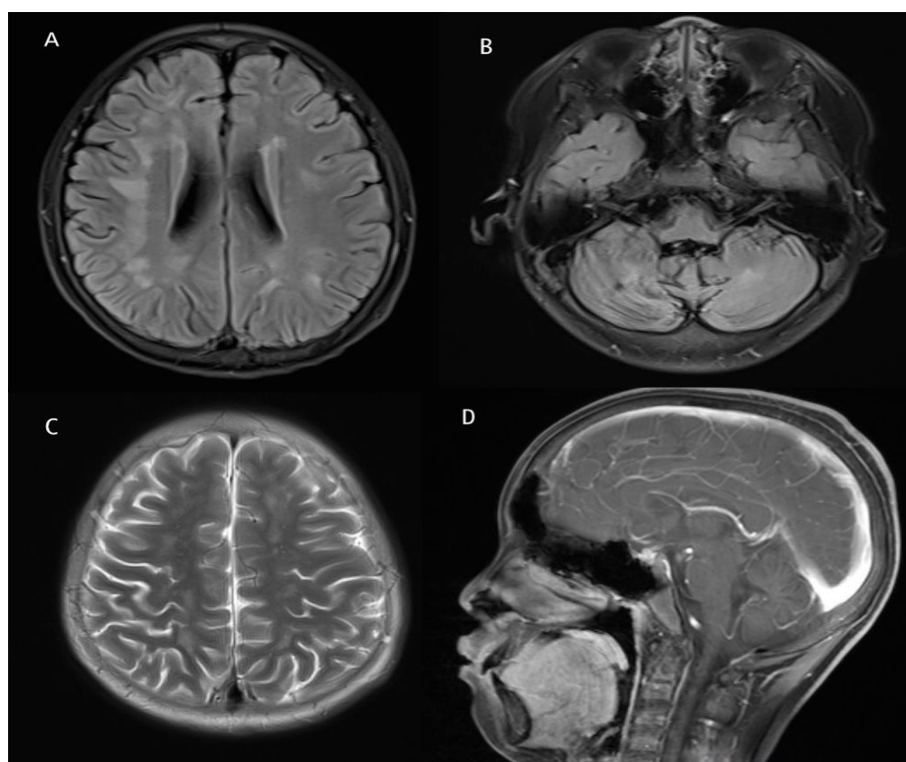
The brain MRI showed abnormal signals in the case of FHL-2. White matter lesions; bilateral cerebellar hemisphere abnormal signals indicated old hemorrhagic sites; bilateral leptomeninges seemed to be slightly thickened with an enhanced signal. (A: Multiple patch-like abnormal signals in the white matter of the bilateral frontal-parietal and lateral ventricles. T2W1 showed high signal and blurred borders. B: Point-like and small-patch abnormal signals could be seen in the bilateral cerebellar hemisphere. T2W1 FLAIR showed low signal, and DWI also showed a weak signal. C: T2 enhanced scan showed a slight thickening with an enhanced signal of the partial bilateral leptomeninges. D: T1 showed slightly thickened and enhanced leptomeninges.)
